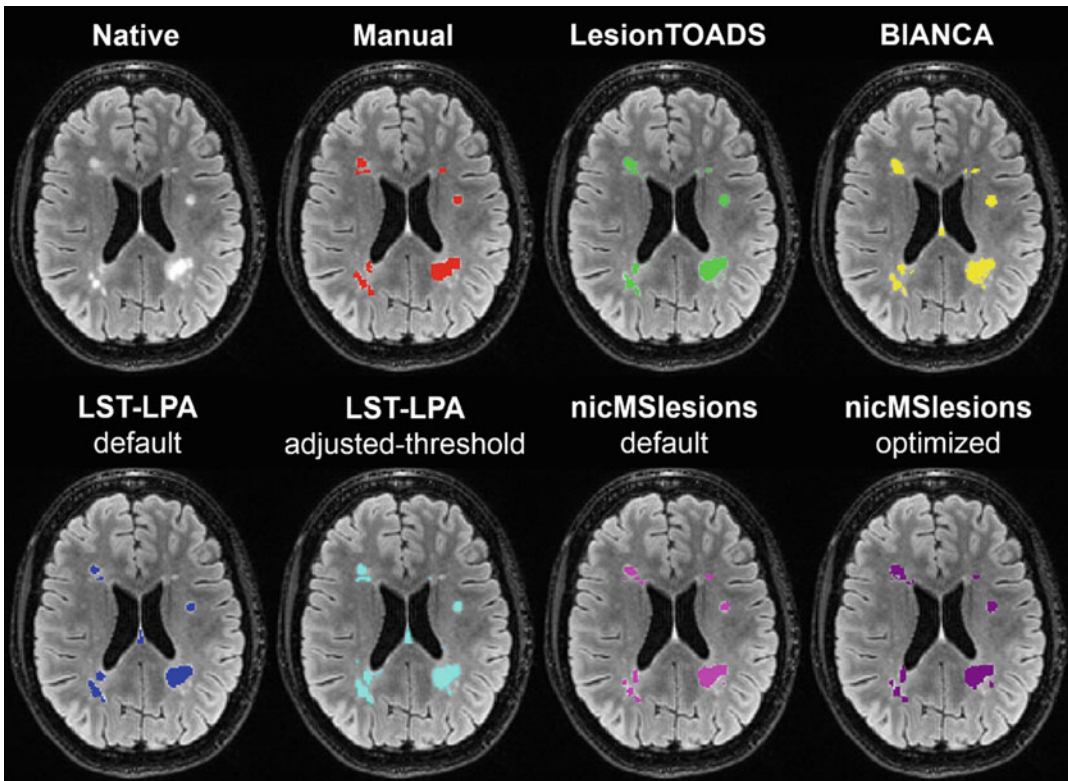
Output examples of four lesion segmentation algorithms and manual segmentation overlaid over FLAIR images of the brain. (Figure adapted from Weeda et al. [40], reprinted with permission from Elsevier)
